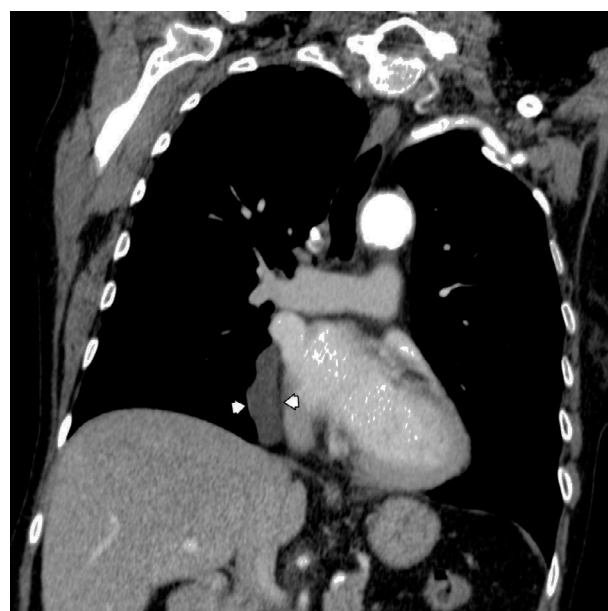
CT sagittal view shows the tubular cystic lesion laterally to the inferior vena cava, extending from the level of the right inferior pulmonary vein to the diaphragm.
